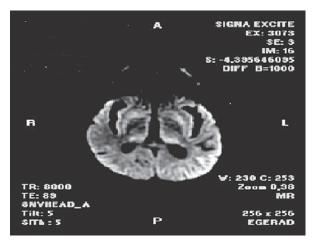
Control brain MRI taken on February 6, 2013: restricted diffusion in bilateral thalamus was clearly depicted on DWI images.
